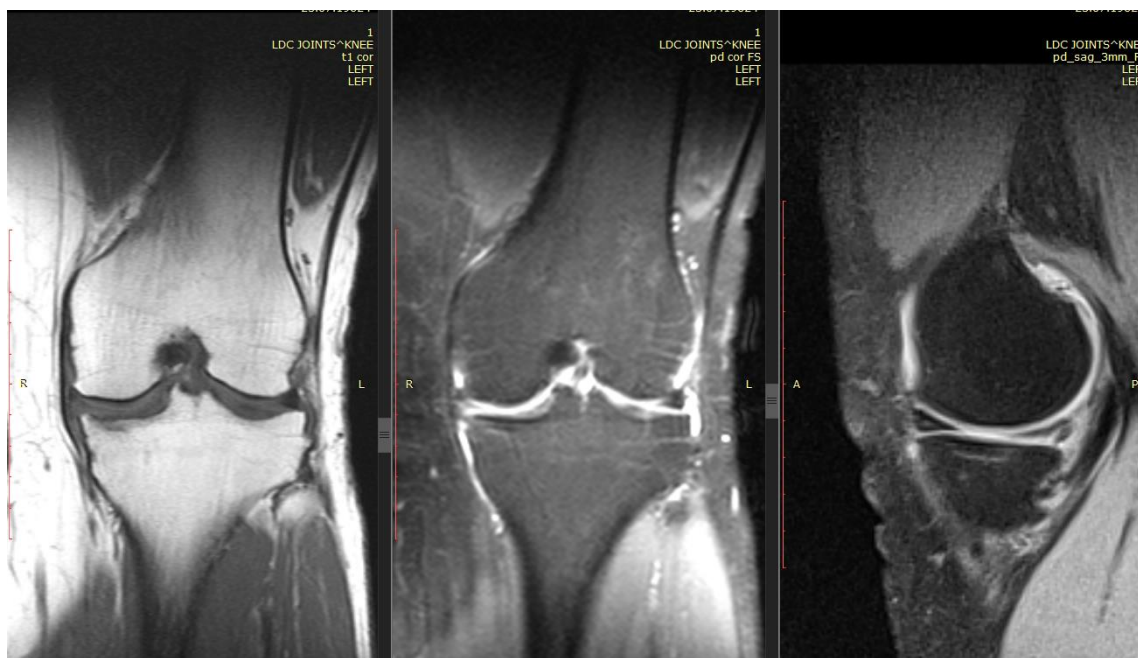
MRI 2 months after treatment.
